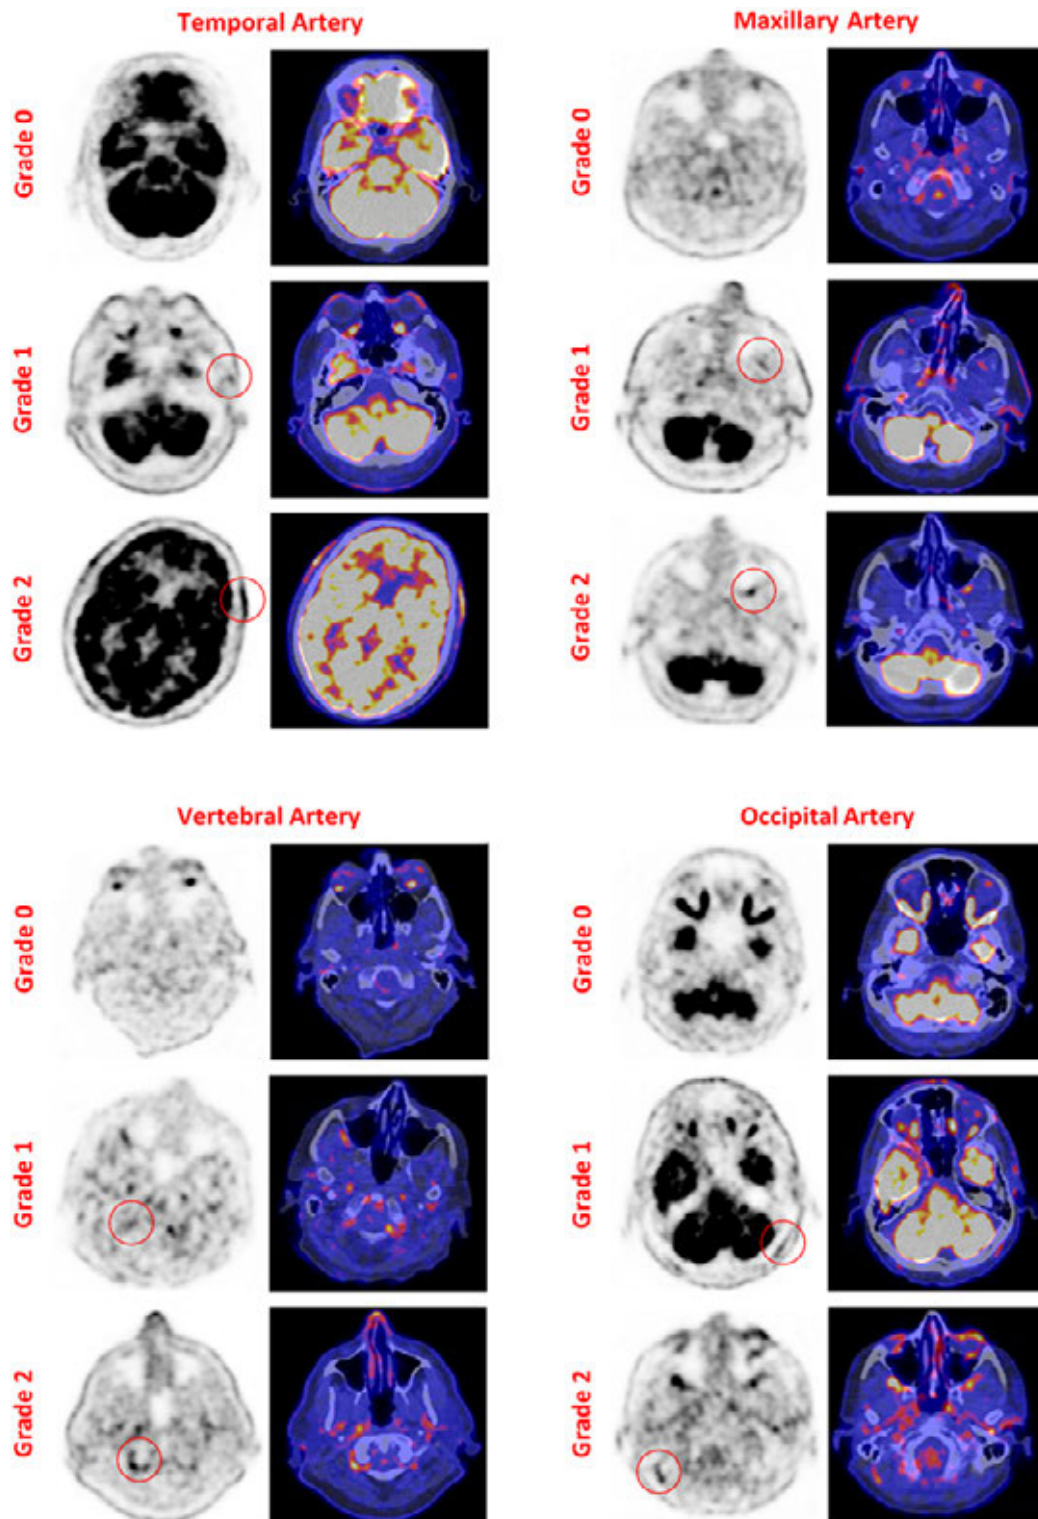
Visual assessment of cranial artery inflammation on FDG-PET/CT. Temporal Artery (TA), Maxillary Artery (MA), Vertebral Artery (VA), and Occipital Artery (OA) were visually scored from 0-2. Scoring definition: 0: no uptake above surrounding tissue; 1: uptake just above surrounding tissue; 2: uptake significantly above surrounding tissue. The red circle denotes the visually determined area of increased uptake.
